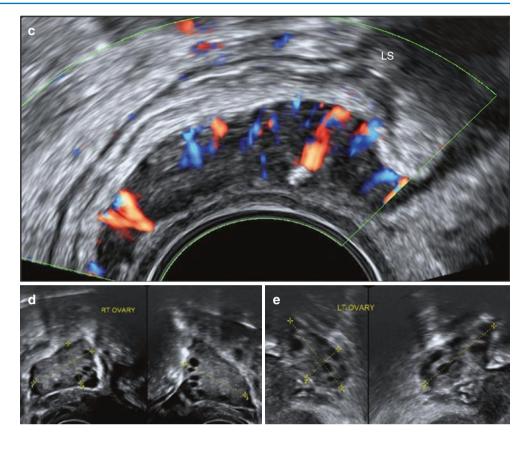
Rectosigmoid DIE in a 32-year-old lady who complained of severe pain in the rectal region with mucoid discharge per rectum during periods. Colonoscopy and ultrasound scans done elsewhere were reported as normal. (a) The anterior muscularis of the bowel loop is much thicker than the posterior muscularis in the area of the DIE nodule. Just within the muscularis, the hyperechoic submucosa (*short arrows*) is seen, and within that is a dark linear area, which is the central lumen of the bowel (*long arrow*). (b) *TS* and *LS* view of the DIE nodule. Typical 'signet ring' appearance is noted on *TS*, (c) DIE nodule showing moderate to high vascularity. (d, e) Both ovaries appeared normal
